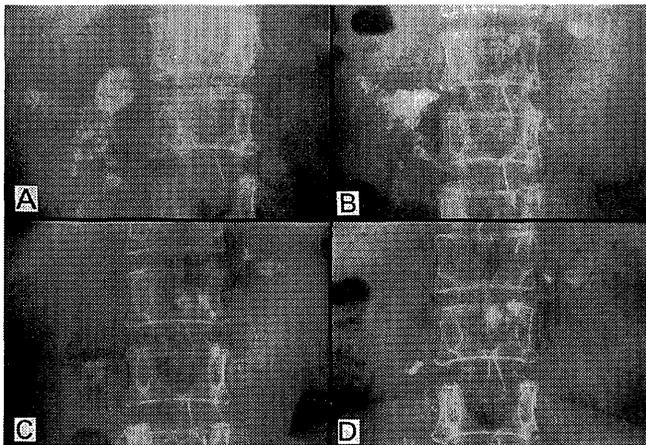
Plain abdominal X-rays in case 2.
